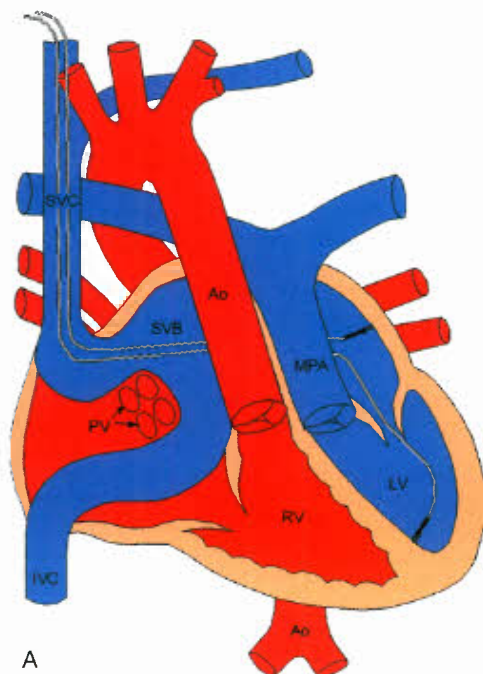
Pacemaker therapy for D-transposition/atrial switch. A: Atrial lead must travel from the superior vena cava through the systemic venous baffle to the remnant left atrium/atrial appendage. The ventricular lead continues across the mitral valve and is fixed within the left ventricle. B: Chest radiograph showing final positioning of the pacemaker leads.
